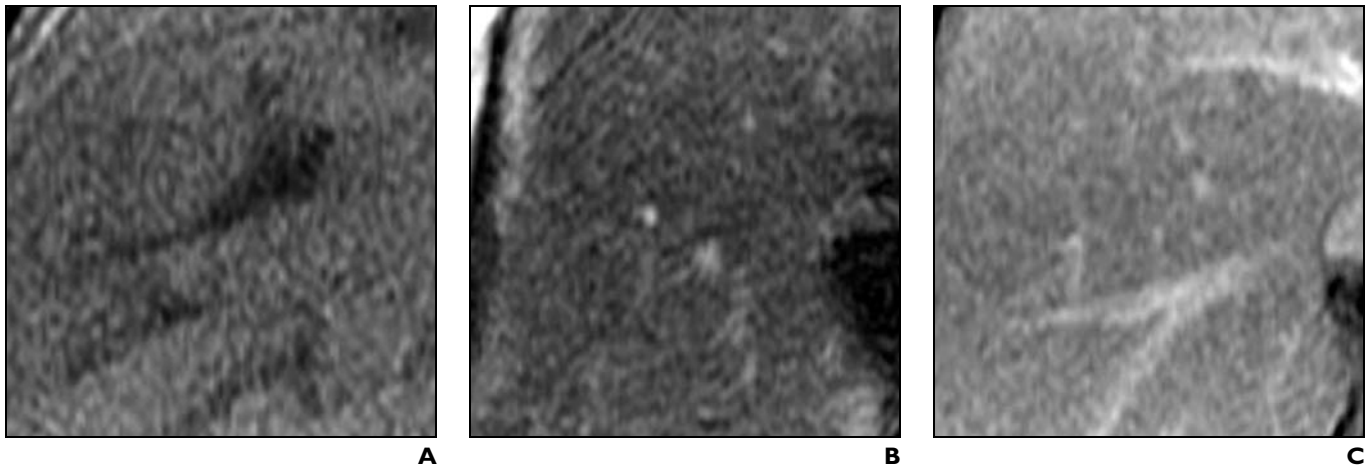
76-year-old man with chronic type-B hepatitis and cirrhosis (F4 on Desmet scale [1]) who underwent partial hepatectomy for solitary hepatocellular carcinoma. A and B, T1-weighted spoiled gradient-recalled echo axial image (TR/TE, 150/1.6) (A) and T2-weighted fast spin-echo axial image (4,286/80) (B) show tiny hypointense nodules, presumably corresponding to regenerative nodules in cirrhosis. C, Gadolinium-enhanced equilibrium phase axial image (150/1.6) shows reticular pattern of enhancement in liver parenchyma that is presumably due to hepatic fibrosis.
